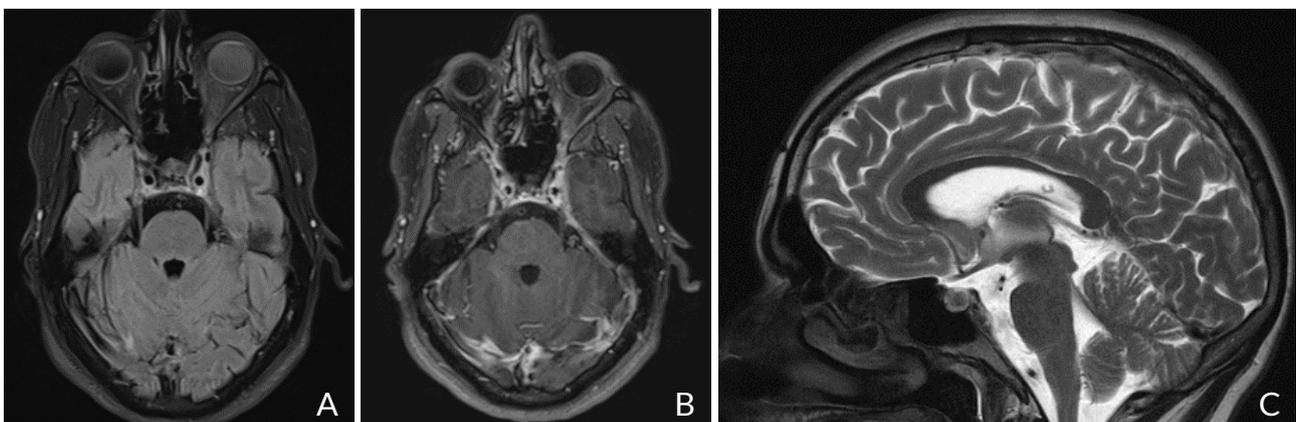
Brain magnetic resonance imaging showing pachymeningeal thickening over temporal lobes and the vertex with diffuse enhancement after injection. A) Axial T2 FLAIR sequence, B) sagittal T2-weighted sequence, C) axial T1-weighted sequence after gadolinium injection
